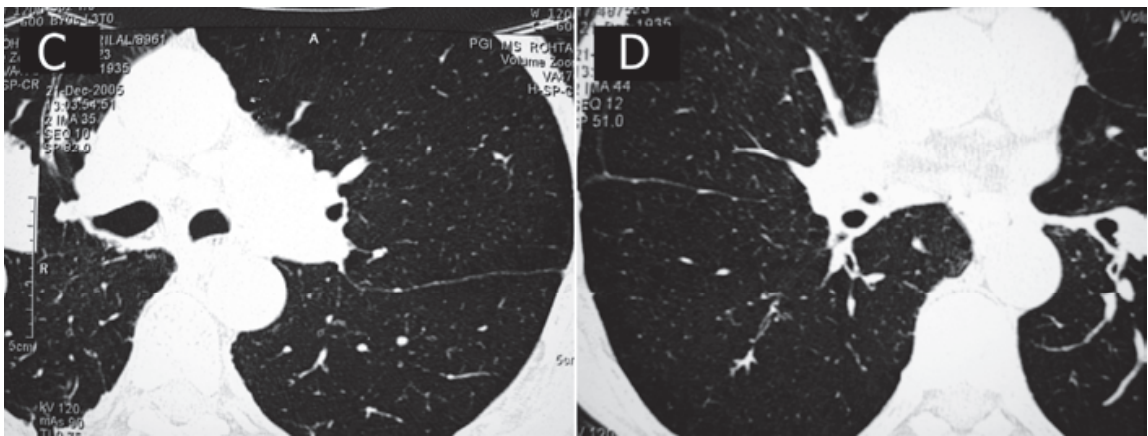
(C-D): Some more HRCT scans showing panacinar emphysema
